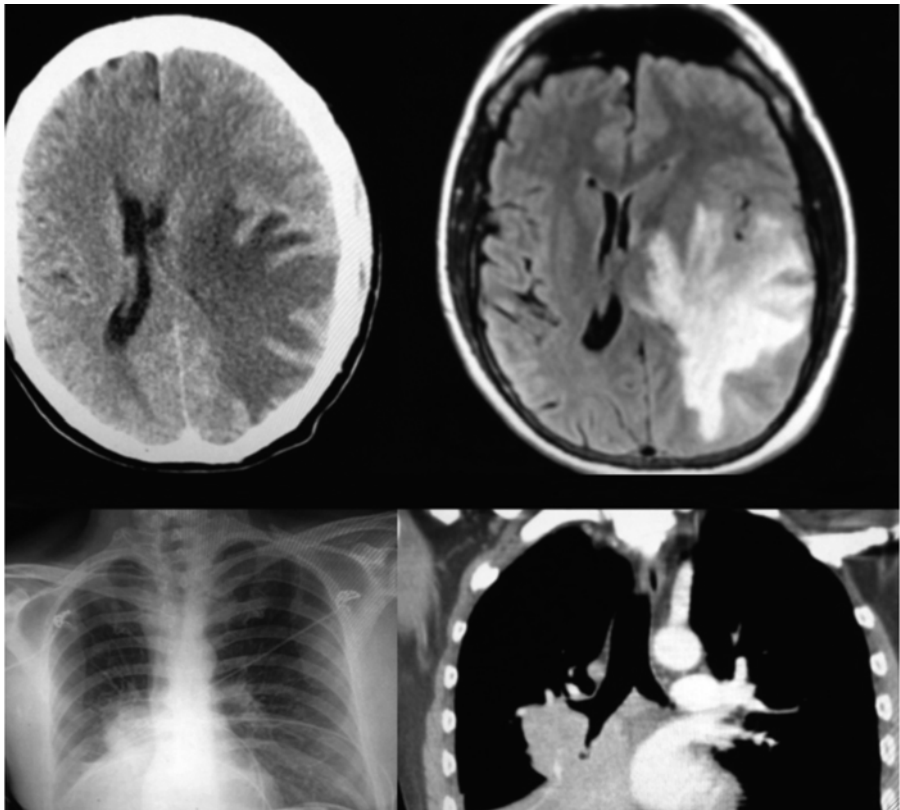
Lung cancer can present initially with neurologic symptoms from metastatic disease; CT at *upper left* and MR at *upper right* reveals an edematous metastatic focus with left to right shift in a 48-year-old smoker who
